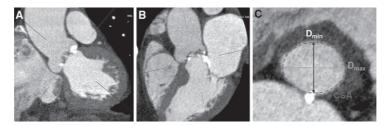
Aortic valve annular dimensions. Multidetector row computed tomography (*MDCT*) permits excellent visualization of the oval-shaped aortic annulus with correct alignment of the orthogonal multiplane reformation planes (a and b). The correct aortic annular plane is defined at the lowest attachment
